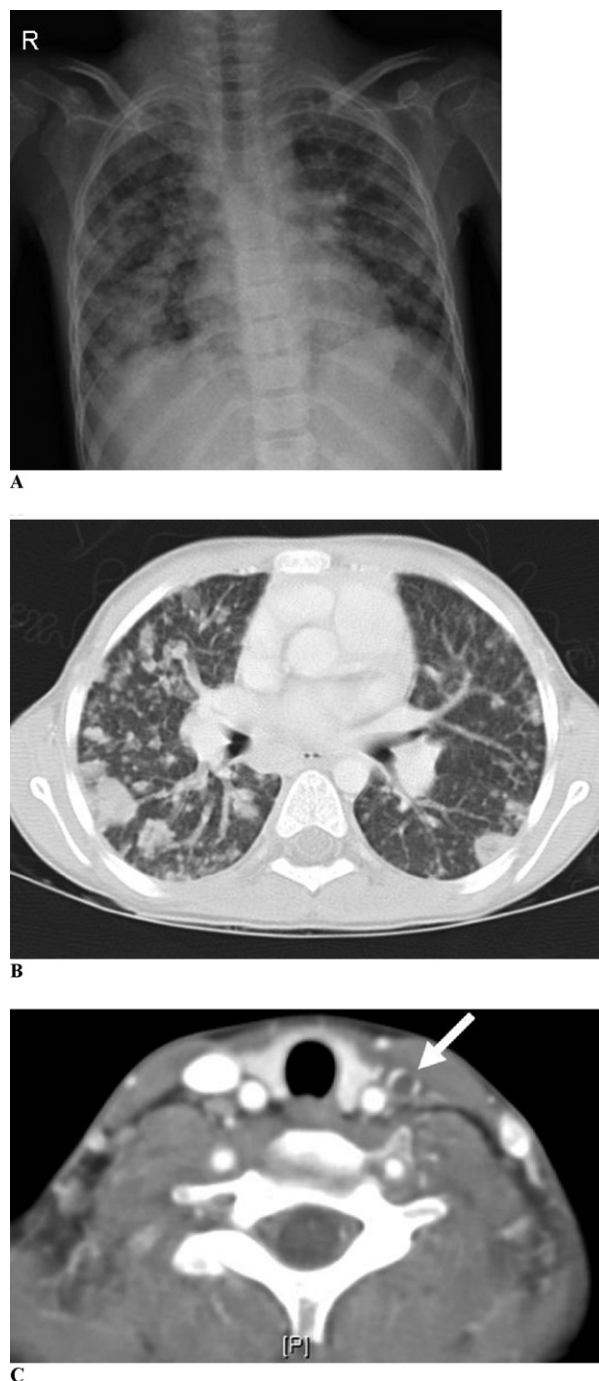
Radiographic findings. (A) Chest radiograph performed in the Emergency Department: bilateral extensive pulmonary infiltrates. (B) Chest computed tomography (CT) scan: Nodular densities, more extensive peripherally and on the right. (C) CT scan of the neck, with contrast: Left internal jugular vein without contrast opacification (arrow).
